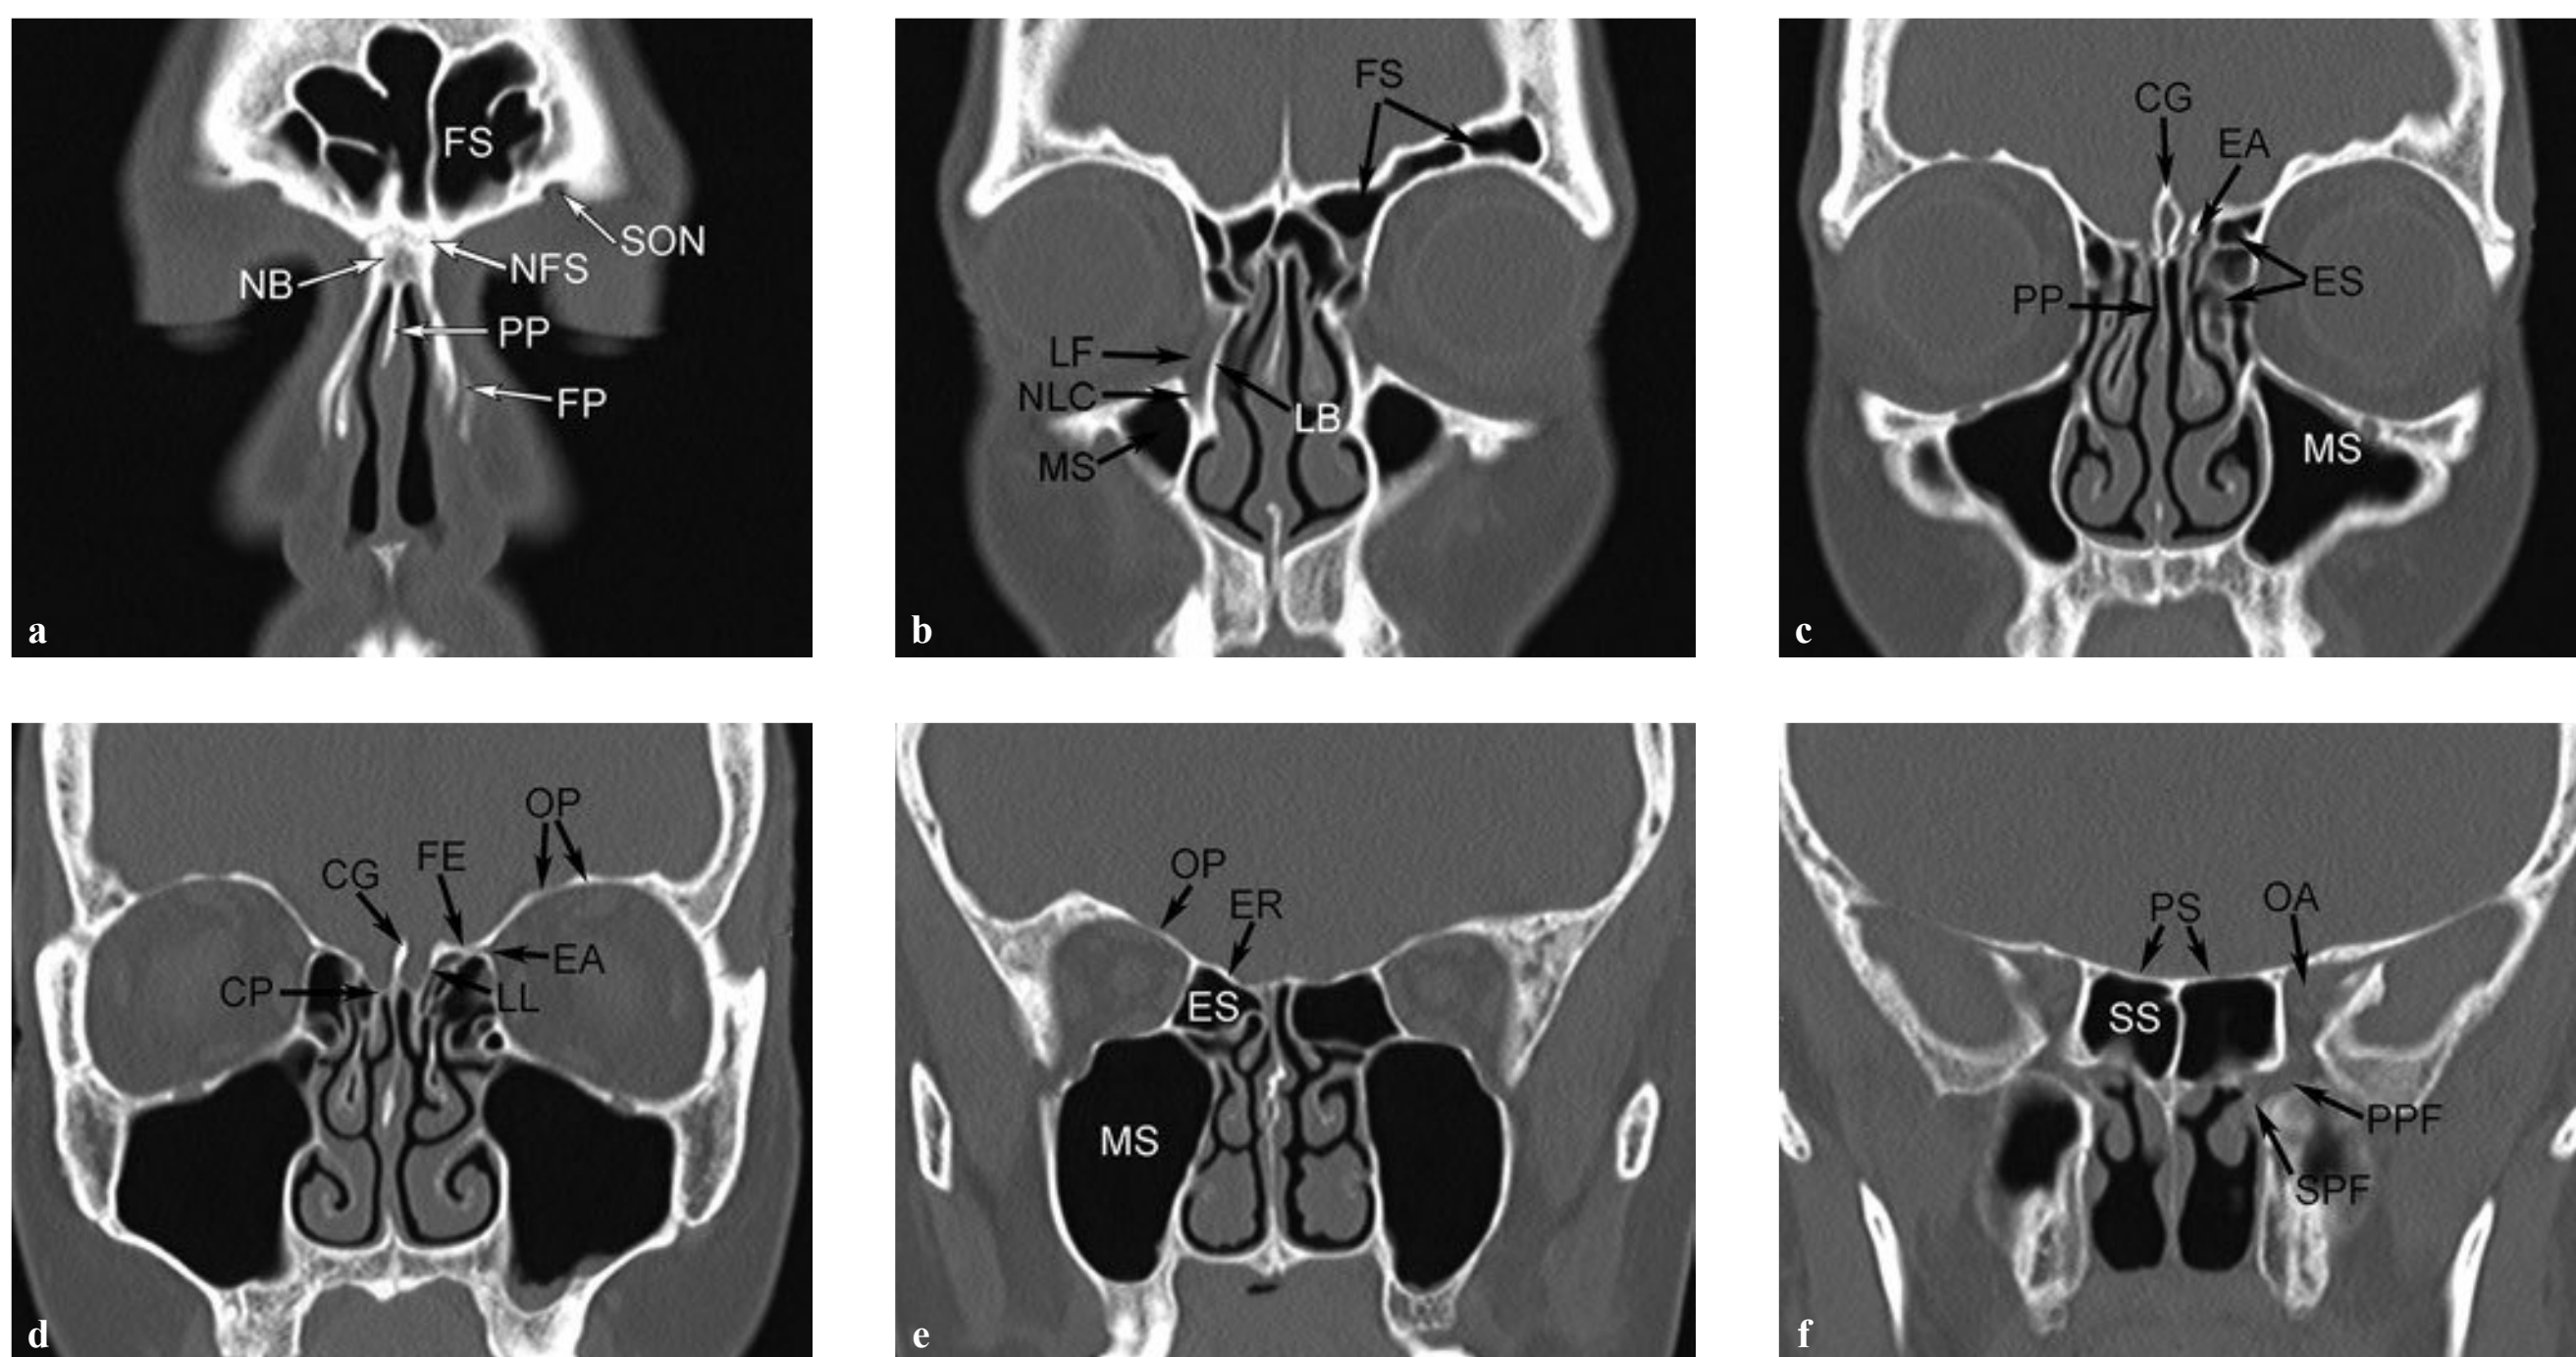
Serial high-resolution computerized tomography (CT) coronal images through the anterior skull base, anterior to posterior. (a) Pneumatized frontal sinus (FS) air cells are seen bilaterally. The supraorbital notch (SON) marks the exit of the supraorbital nerve and associated vessels from the orbit to the forehead. The paired nasal bones (NBs) merge anteriorly at the nasal bridge and fuse superiorly at the nasofrontal suture (NFS). The perpendicular plate (PP) of the ethmoid bone forms the bony nasal septum superiorly. The inferior and lateral bony support of the nose is provided by the frontal process (FP) of the maxilla. (b) Frontal sinus (FS) air cells extend posteriorly above the orbital roof. There is a depression, the lacrimal fossa (LF), in the inferior and medial orbit that houses the lacrimal sac. The medial wall of the lacrimal fossa is formed by the lacrimal bone (LB). The lacrimal fossa is contiguous with the bony nasolacrimal canal (NLC). (c) More posteriorly, the crista galli (CG) is seen as a thin bony protrusion in the sagittal plane. The perpendicular plate (PP) of the ethmoid bone forms the bony nasal septum superiorly. The ethmoid sinus (ES) and maxillary sinus (MS) are seen at this level. A small foramen can be seen at this
